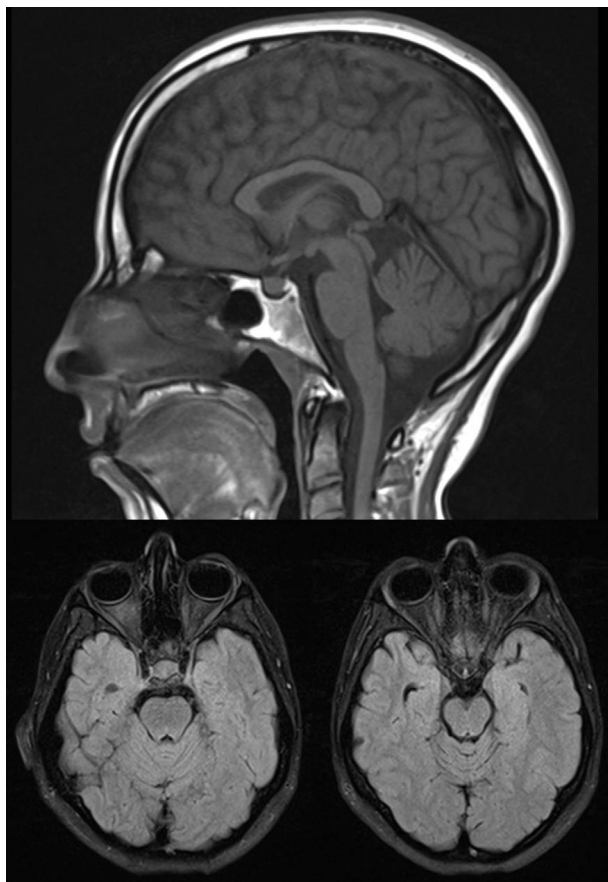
MRI of the brain showing mild cerebellar atrophy with special involvement of cerebellar medline structures.
